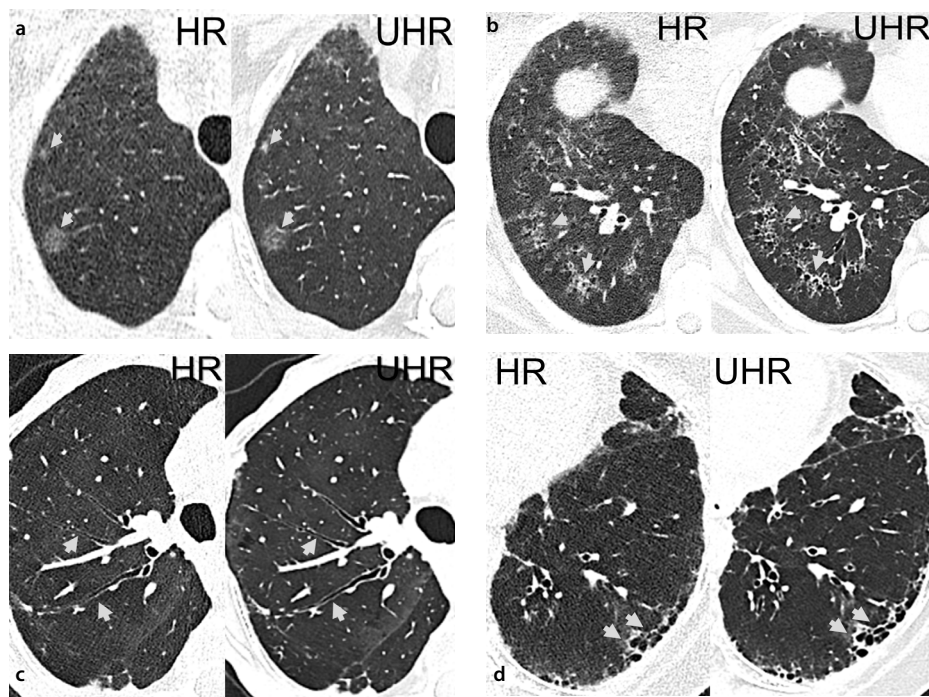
Non-contrast HR (left) and UHR (right) chest photon-counting detector CT scans at the same level represent interstitial abnormalities (indicated by gray arrows): upper-zone GGO (a), middle-zone peribronchovascular fibrosis (b), middle-zone bronchiectasis (c), and lower-zone honeycombing (d). Images are derived from four different RA patients with different patterns of parenchymal involvement: respiratory bronchiolitis interstitial lung disease (ILD) (a); desquamate interstitial pneumonia-ILD (b); non-specified ILA (c); and dUIP (d). UHR, ultra-high-resolution; HR, high-resolution; CT, computed tomography; GGO, ground-glass opacity; RA, rheumatoid arthritis; ILA, interstitial lung abnormalities; dUIP, definitive usual interstitial pneumonia.
